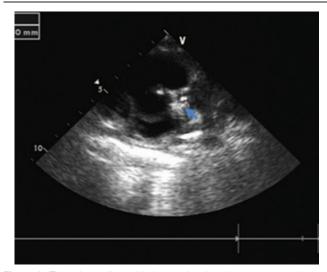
The echocardiographic image showing the aneurysm and mural thrombus in the aneurysm (the arrow).
